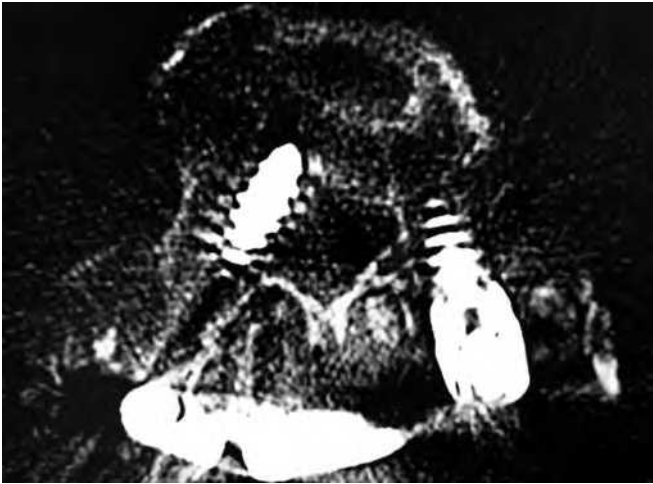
The patient underwent lumbar decompression and instrumented fusion. The postoperative computed tomography showed a medial breach of the right L4 pedicle screw. The patient showed neither complaint nor neurodeficiency.
